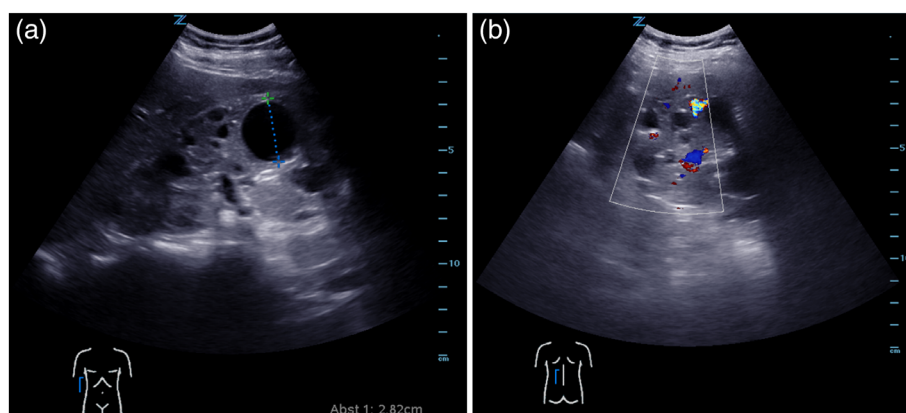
Ultrasonography of kidneys: (a) multiple renal cysts detectable in right kidney (longitudinal view, front). (b) Color Doppler analysis of left kidney; Perfusion is detectable in the vessels, but not in the cysts (longitudinal view, back)
